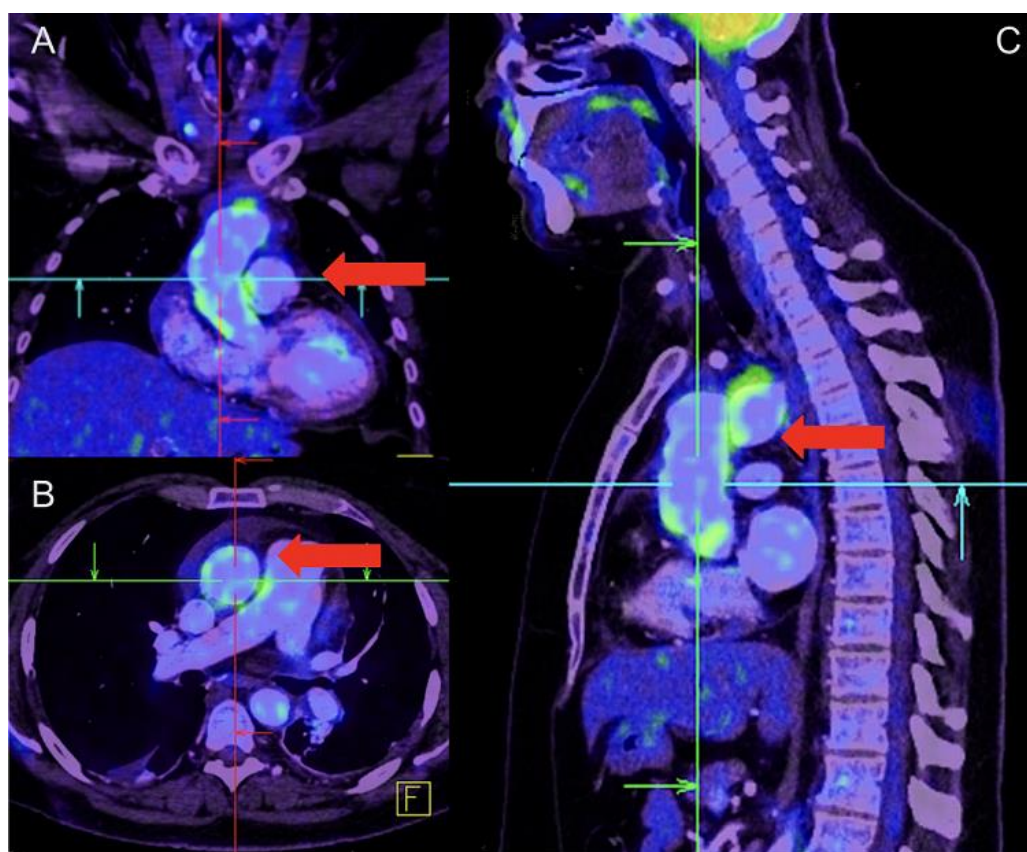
PET Study with 18-FDG
